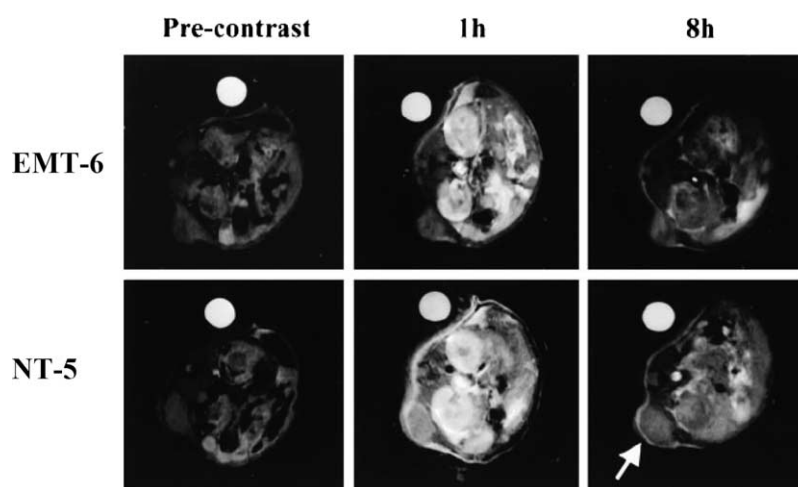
MR T1-weighted images of control EMT-6 (which do not express HER-2/*neu*) and NT-5 tumours (labelled with a biotinylated monoclonal antibody to HER-2/*neu*) obtained before administration of the contrast agent (avidin-GdDTPA conjugate) and at 1 h, 8 h after contrast. Arrows show enhanced signal from the tumour at the 8 h time point for the HER-2/*neu* expressing NT-5 tumour [1].
